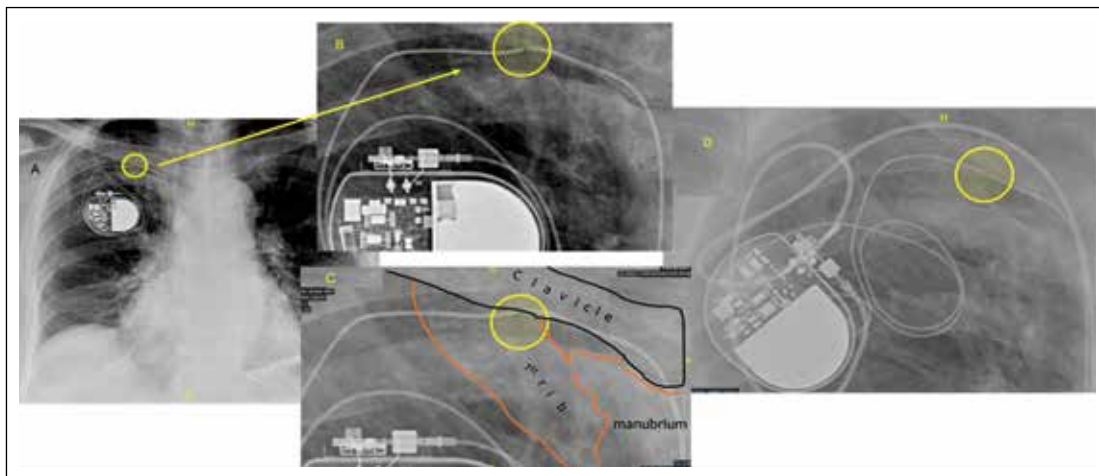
This frontal chest radiograph (A) of an elderly patient who had CHB and underwent single chamber lead in the past and presented with an episode of syncope and fall. On interrogation, the patient had a loss of capture with high impedance with a ventricular escape rhythm. Chest radiograph showed discontinuity in the ventricular lead at the position of the clavicle and 1st rib interface, likely due to the chronic crush insult (B, C, D). The lead was capped and buried within the pocket, and new ventricular lead was inserted.
